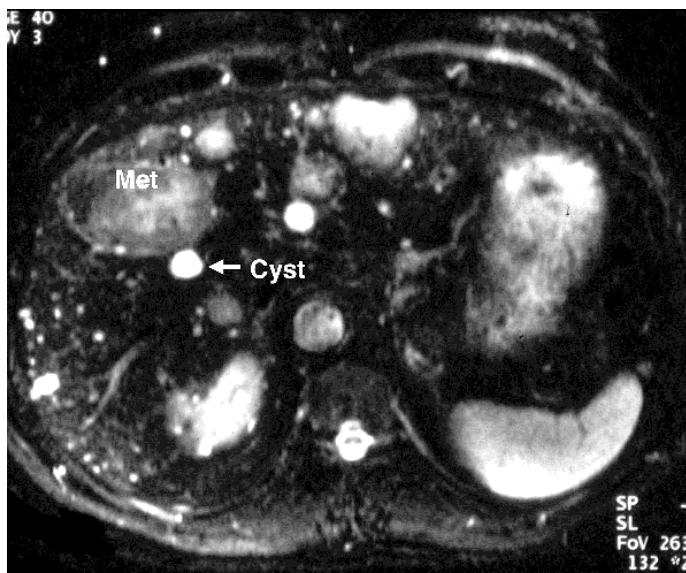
T2-weighted liver MR in a patient with both benign liver cysts and solid liver metastases. A properly selected TE helps differentiate cysts from solid masses. Most liver protocols use a TE of approximately 100msec for this purpose.
